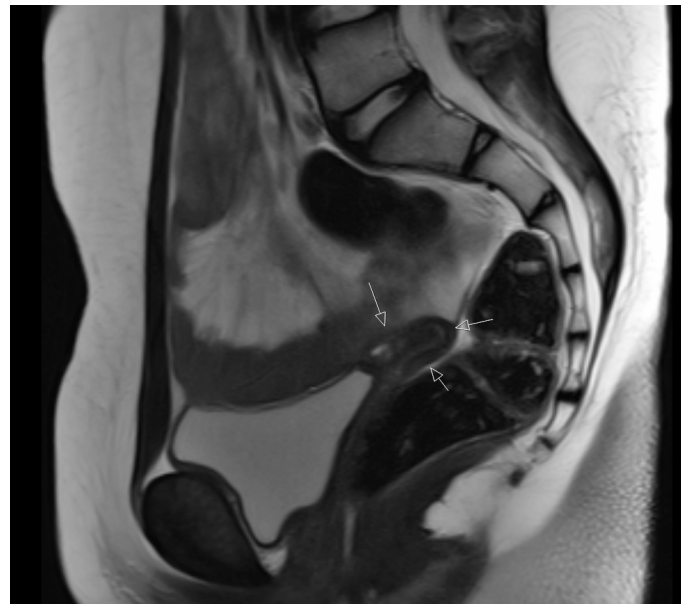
Pelvic MRI image of a 15-year-old patient with mixed gonadal dysgenesis. The patient's chromosome analysis results in 46 XY karyotype. The MRI shows the uterus (white arrows).
